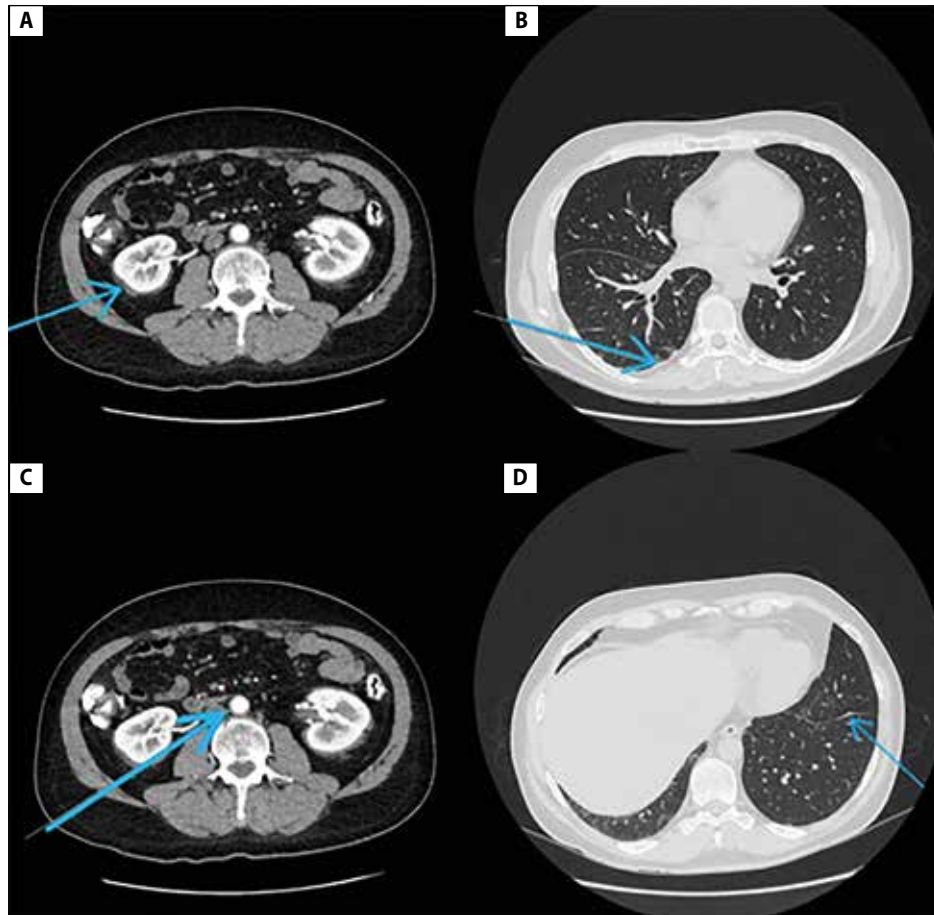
CT imaging of the patient. A. CT of the abdomen in the axial cross-section showing hypodense alteration surrounding the right kidney, corresponding to the “hairy kidney sign” (soft tissue ring of perirenal infiltration – pathognomic sign to ECD); B. CT of the chest in the axial cross-section showing pleural fibrosis; C. CT of the abdomen in the axial cross-section showing aortic wall thickening consistent with the “coated aorta sign” (circumferential infiltration of the aorta); D. CT of the chest in the axial cross-section showing interlobular septal thickening
